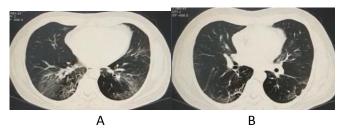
(A & B): Axial chest CT images of adult patient 3 months after recovery from initial infection with Covid-19, showing fibrous stripes with reticular parenchyma opacification and ground glass appearance seen in the lower lobes of both lungs. Both images have the same window level of – 600 and window width of 1600
